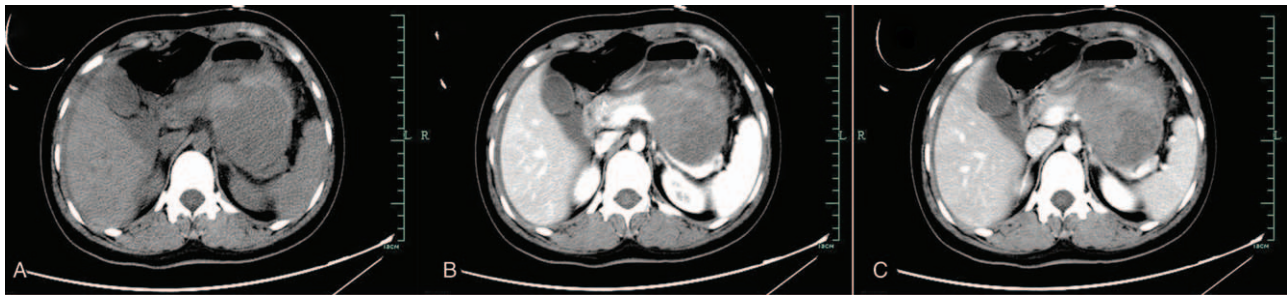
The CT scan demonstrated a cystic lesion (about 95 × 75 mm) located in the pancreas.
